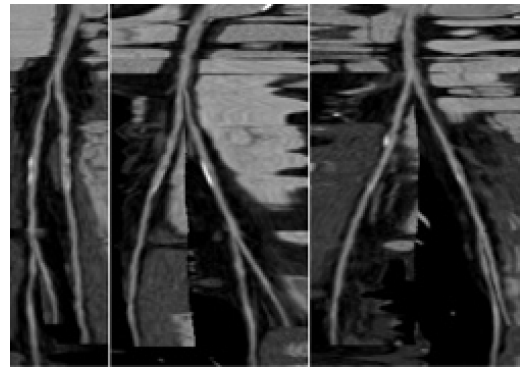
Advanced CPRs of the vessels of a peripheral CTA dataset. (a) shows stretched mpCPR. (b) presents the untangled CPR of the same view. (c) displays a side view using again stretched mpCPR. (d) depicts the untangled CPR of the side view. (From [KWFG03])
